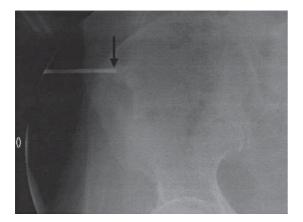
X-ray during POP in patient 5, showing the needle (*arrow*) and bone cement injected into the right ilium
